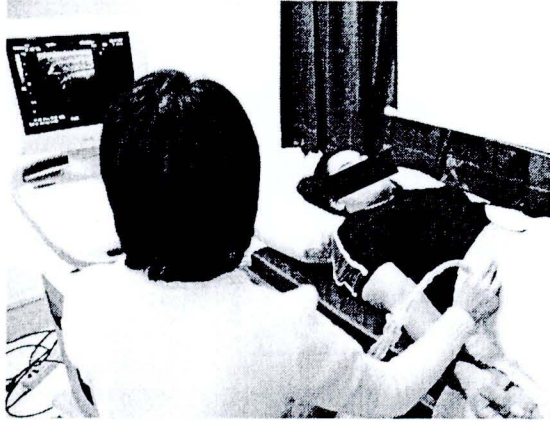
Ultrasound imaging with a 12-MHz linear array was used to measure lateral abdominal muscles (LAM) thickness. The ultrasound transducer was aligned perpendicular to the right side of anterolateral abdominal wall.
